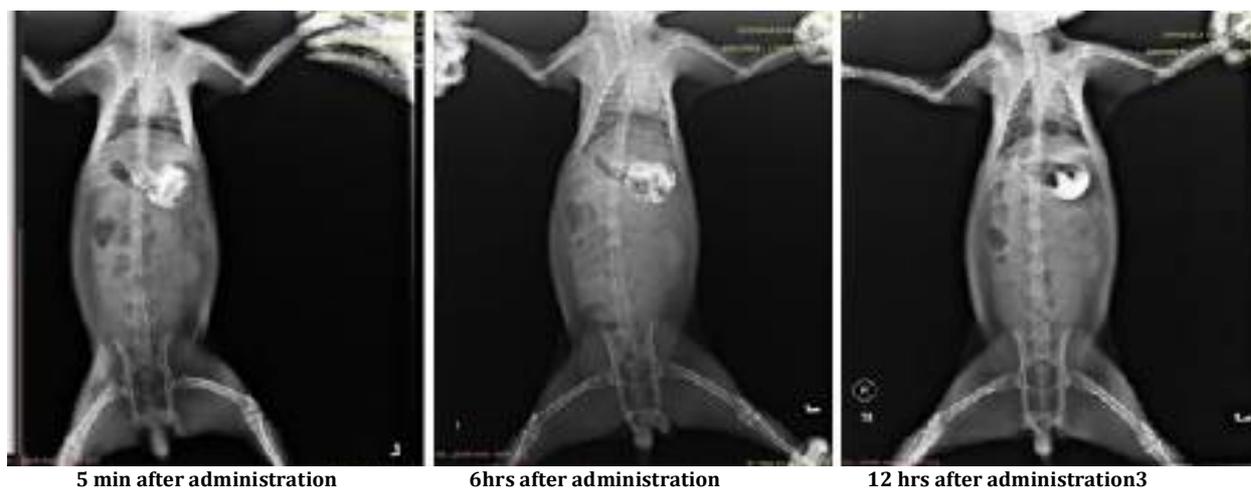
X-ray images after administration
